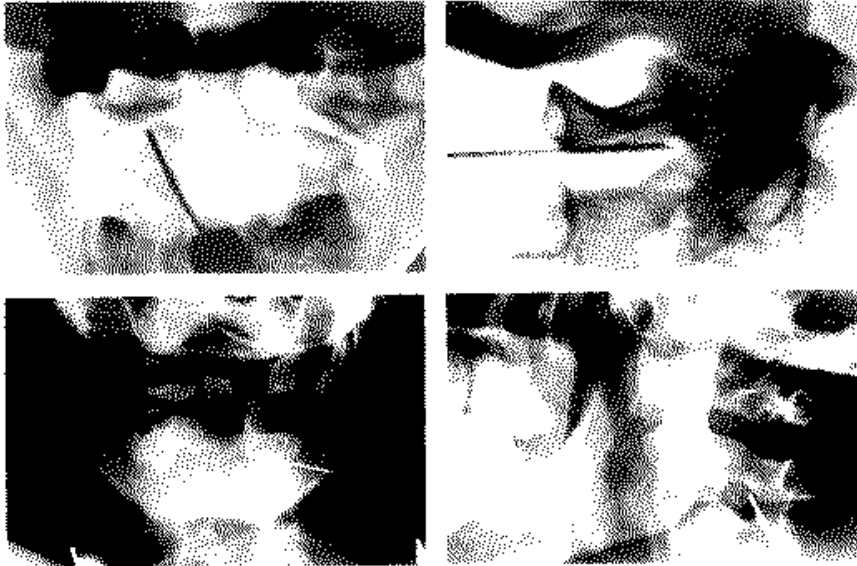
The needle tip position for a C2 anaesthetic root block is shown in an AP and lateral X-ray, upper left and upper right. The needle tip position for a C3 root block is shown in an AP and lateral X-ray, lower left and lower right.
